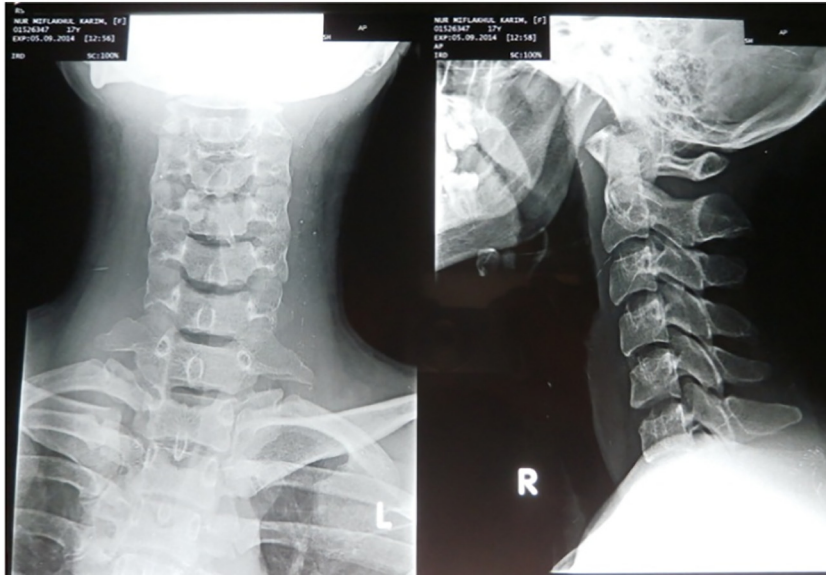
AP and lateral view of cervical spine X-ray. There is no fracture and dislocation found here. The alignment and pretracheal soft tissue is also looks normal.
